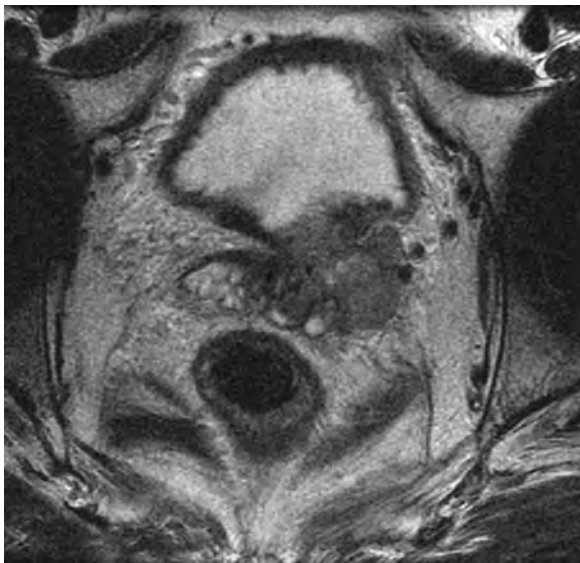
Axial T2-weighted magnetic resonance image shows tumor involving the seminal vesicle and bladder base and extending into the adjacent fat.
